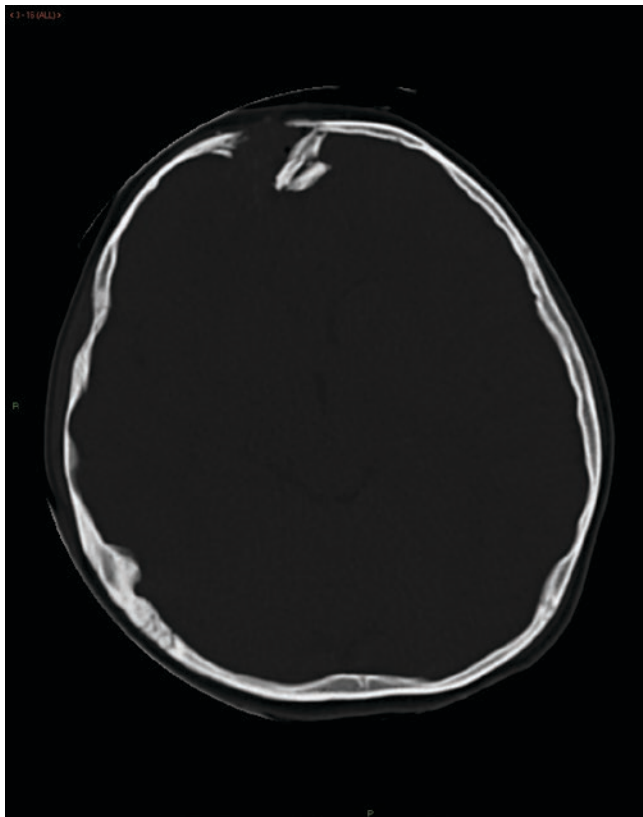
Axial CT image shows a comminuted right frontal bone fracture with depressed bone fragments
